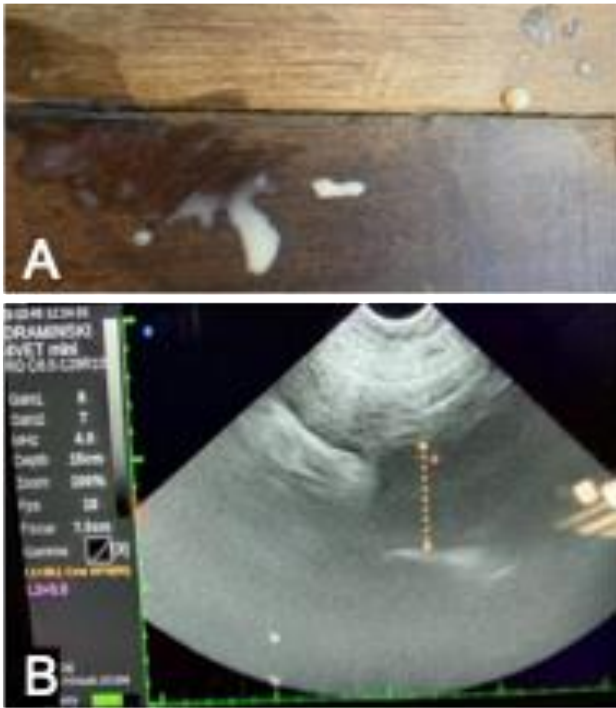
Clinical evidence observed in Zuri, an 8-year-old female white lion (*Panthera leo*) managed in Sunway Lagoon Wildlife Park. (A) Caseous discharge at the night stall floor; (B) Fluid-filled tubular structure observed by abdominal ultrasonography.
